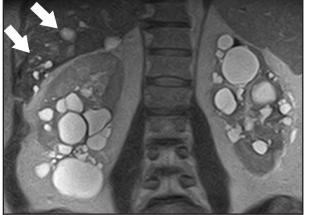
A 45-year-old man with autosomal dominant polycystic kidney disease (ADPKD). Coronal T2-weighted MR image demonstrates bilateral enlarged kidneys with multiple renal cysts and hepatic cysts (arrows) consistent with the diagnosis of ADPKD.
